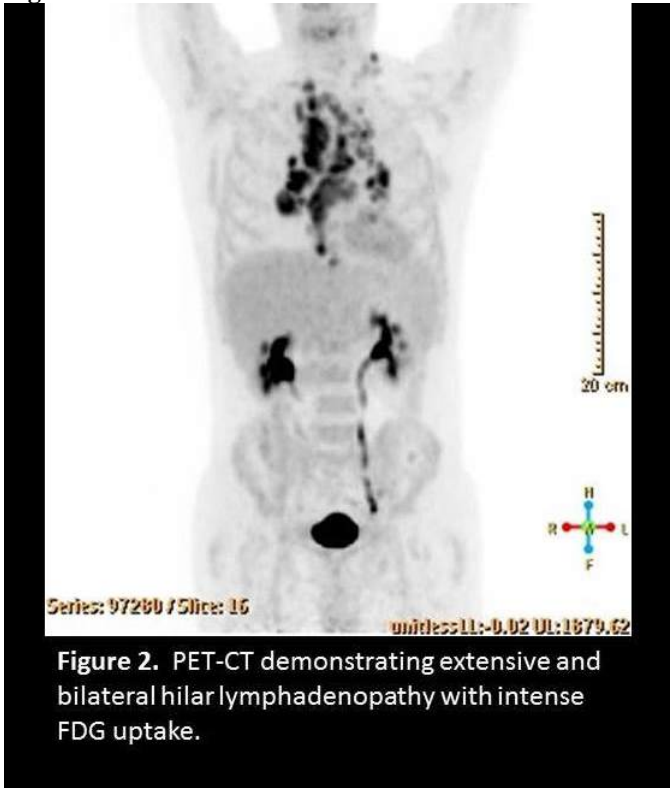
PET-CT demonstrating extensive and bilateral hilar lymphadenopathy with intense FDG uptake.
